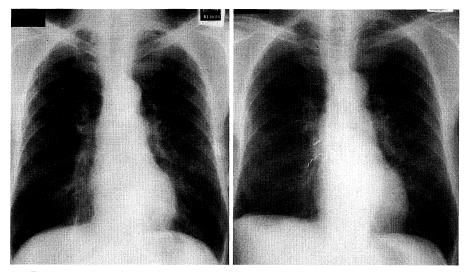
Preoperative and postoperative (50 months after sleeve right S6 segmentectomy) chest x-ray films of a 63-year-old man.
